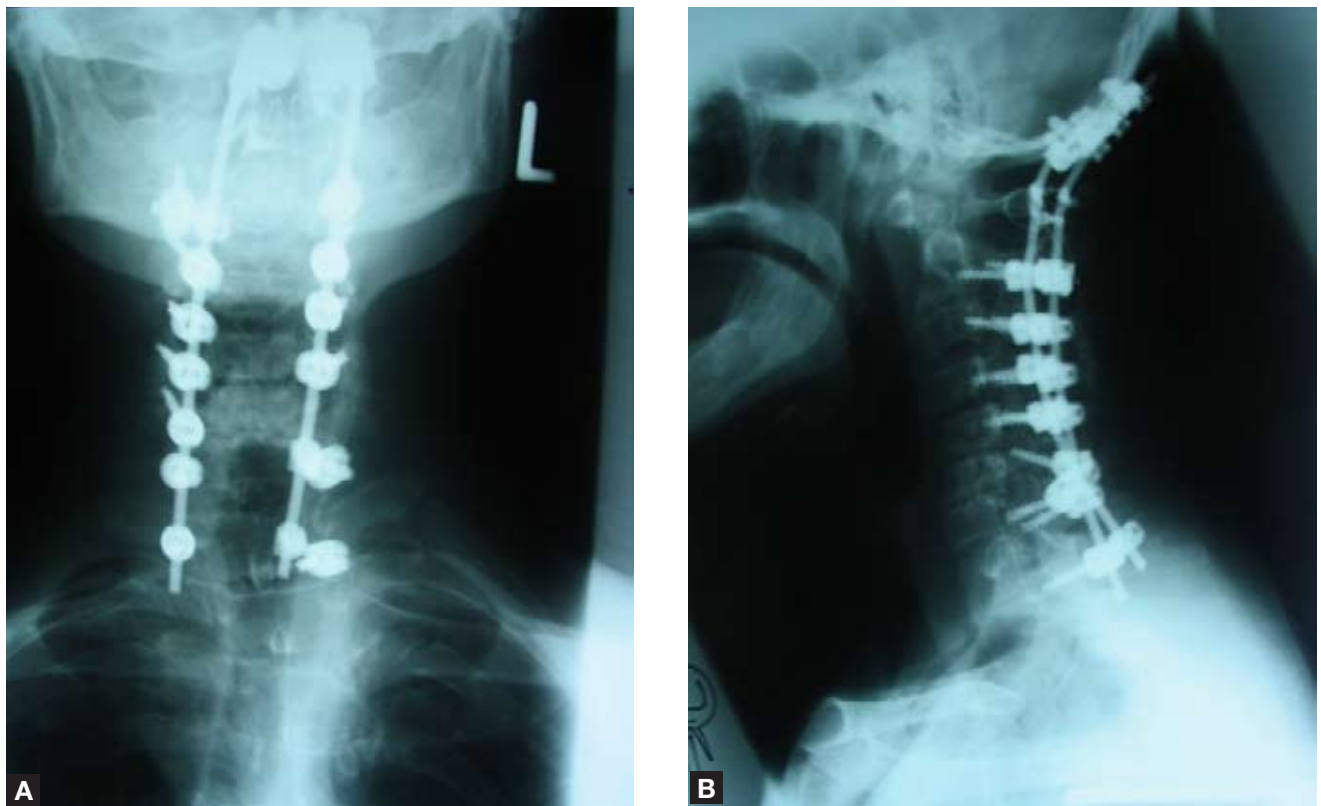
Postoperative anteroposterior (A) and lateral (B) x-rays of the patient in Figures 6 and 7 show treatment by means of occiput-to-T1 fusion. A combination of screws and wires was used to restore a normal relationship between C1 and C2 and to stabilize all involved segments of the cervical spine. Images courtesy of John Olsewski, MD, Bronx, New York.
